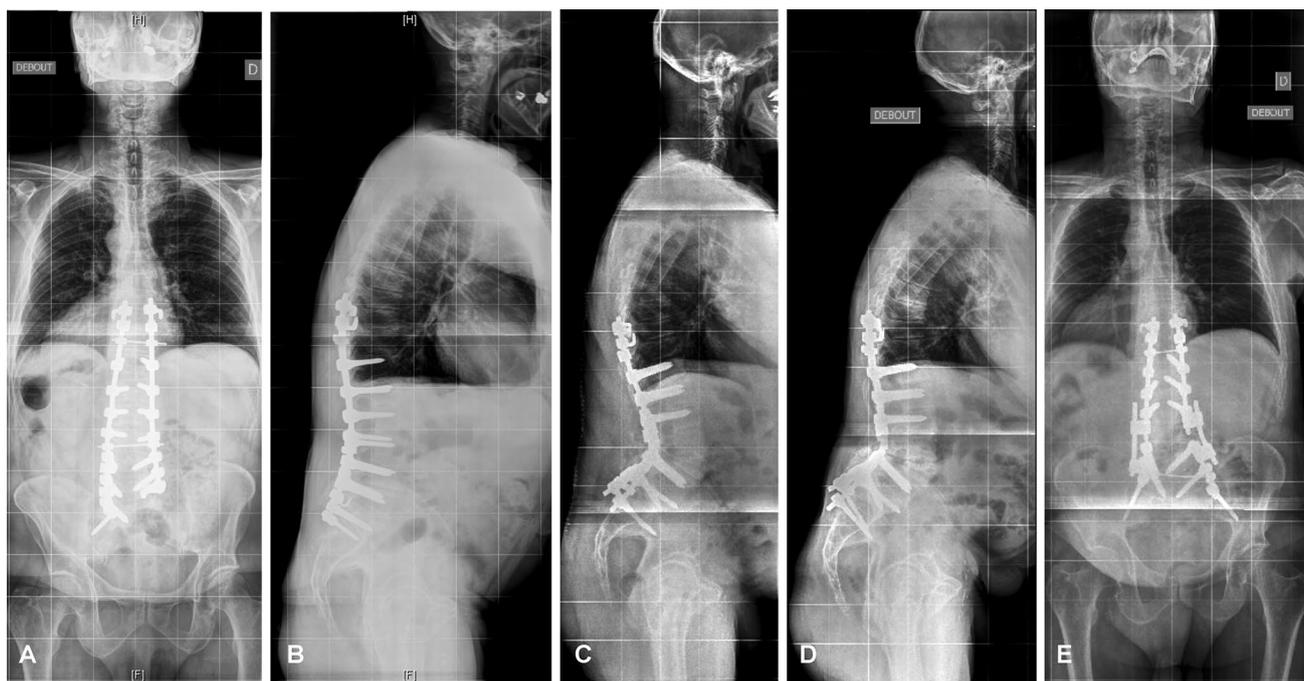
A 64-year old male with flat back after posterior fusion T10-sacrum, preoperative posterior–anterior (a) and lateral (b) radiographs prior revision surgery showing anterior imbalance: SVA C7 136 mm, thoracic kyphosis 41°, lumbar lordosis 27°, pelvic incidence 52°, pelvic tilt 32°, sacral slope 27°. Postoperative lateral radiograph (c) after PSO at L4 showing a normalization of spinopelvic parameters but a global kyphosis increase in the non-instrumented thoracic
